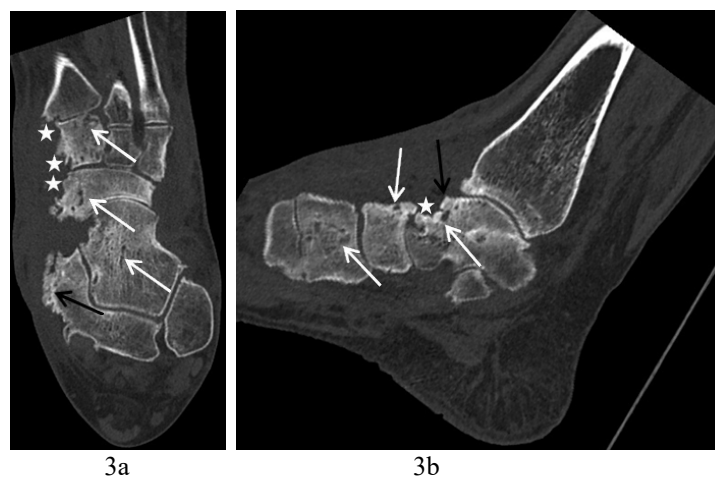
CT images of Mycetoma. FINDINGS: coronal(3a) and sagittal(3b) CT MPR images demonstrate moth-eaten cortical erosion (asterisk), cystic osteolytic lesions and cavitation (white arrow) of multiple bone involvement, reactive sclerosis, periosteal proliferation (black arrow) and irregular osteophytosis, joint space narrowing and osteopenia. TECHNIQUE: Axial CT, 50mAs, 120kV, 1mm slice thickness.
